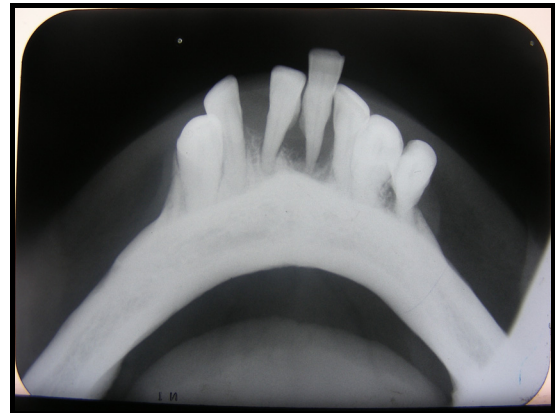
Mandibular Occlusal view Radiograph showing alveolar bone loss
